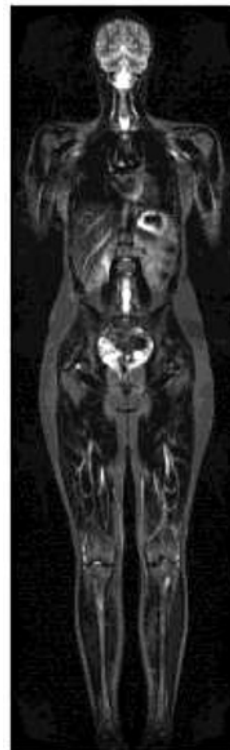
WB-MRI coronal STIR image of a 17-year-old female undergoing chemotherapy for Hodgkin lymphoma, demonstrating steroid-related multifocal osteonecrosis.
